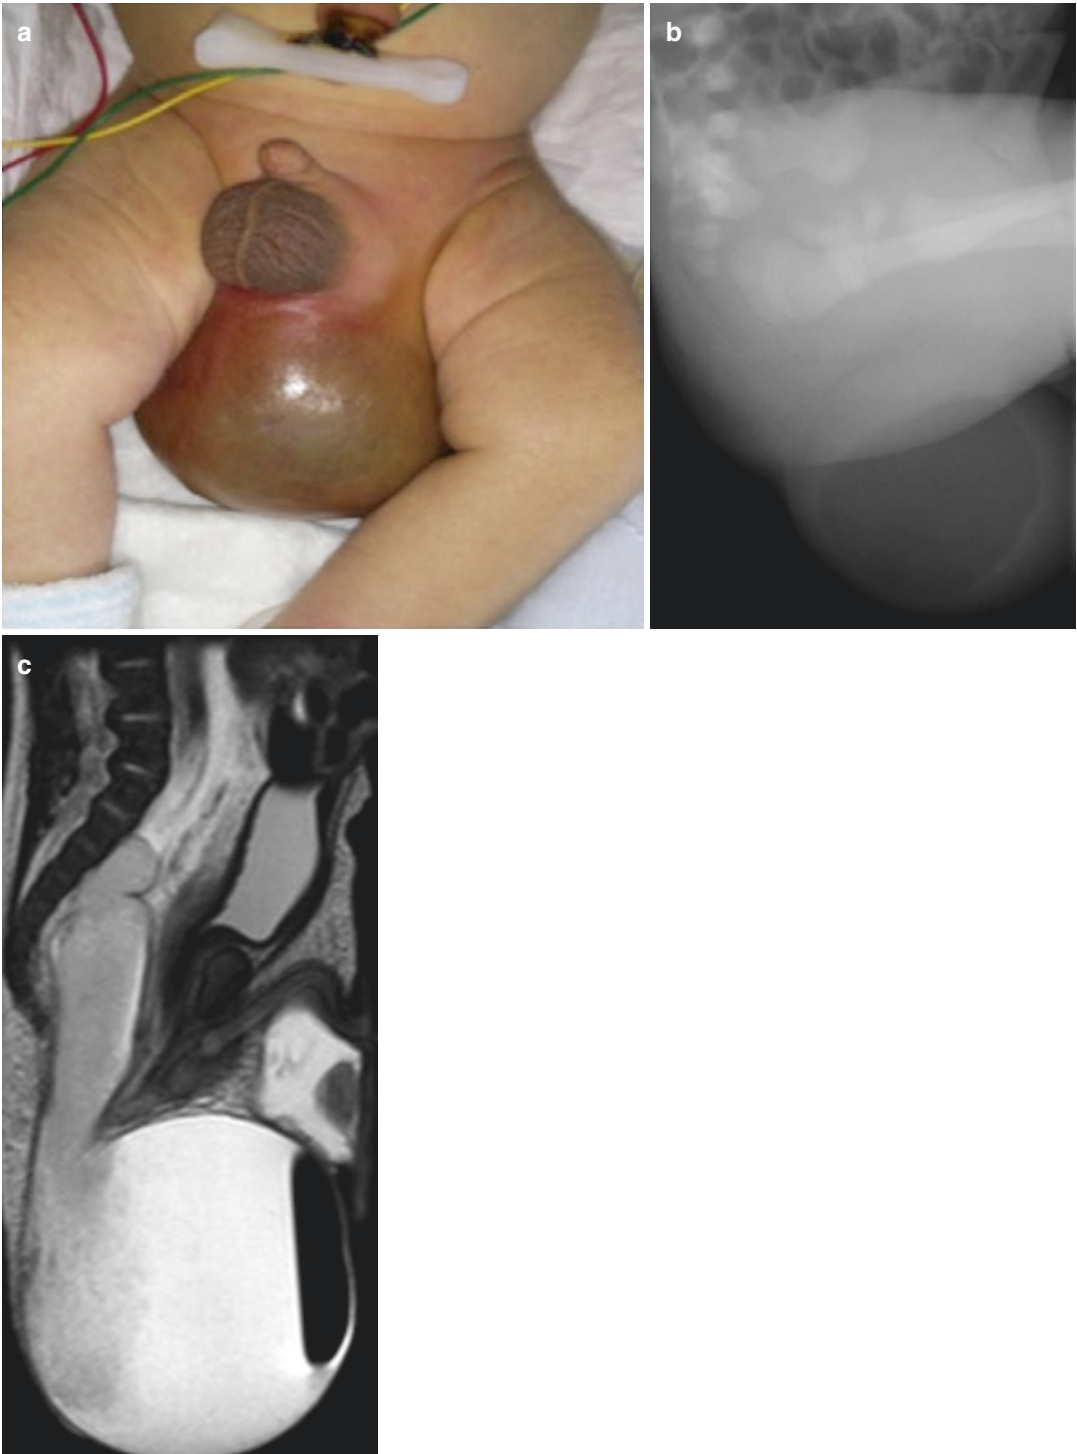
Neonatal large external mass corresponding to a rectal duplication diagnosed prenatally (Courtesy C. Fayard MD). (a) Large extraperineal soft mass. (b) The left lateral decubitus radiograph shows a partially aerated mass. (c) The sagittal T2 weighted MR imaging confirms that the mass corresponds to a duplicated rectum prolapsed through the perineum
